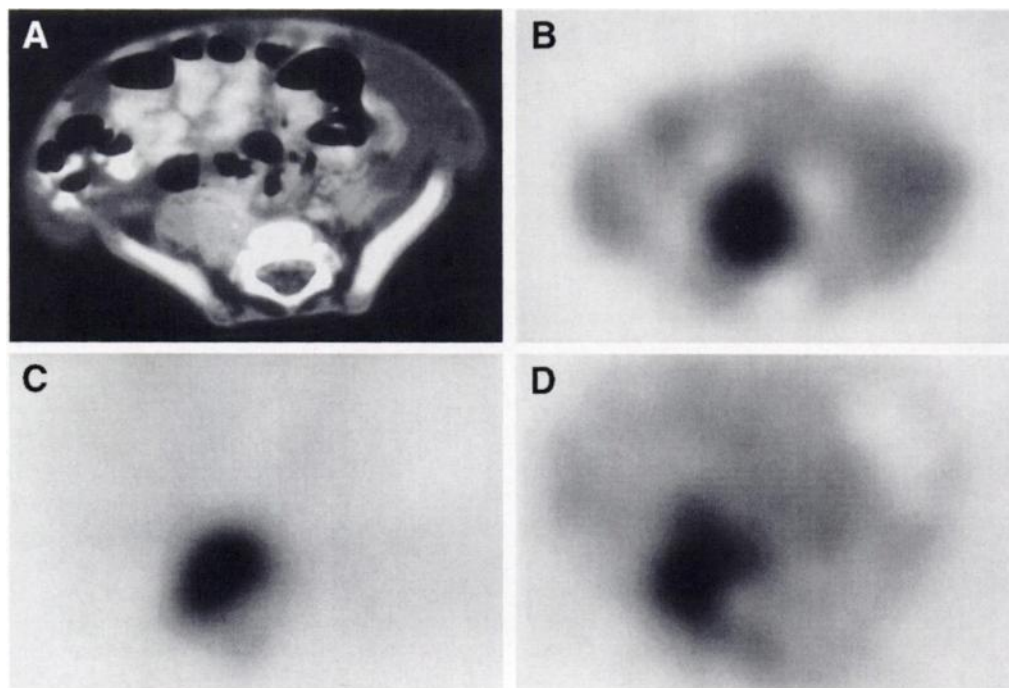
Patient 3. (A) CT scan of the pelvis at 6 mo of age following surgical debulking: There is abnormal soft tissue with speckled calcification in the right posterior pelvis. (B) MIBG-SPECT scan at 24 hr shows uptake into the tumor. (C) HED-PET scan 20 min postinjection. There is excellent uptake within the neuroblastoma, and the image appears similar to the MIBG-SPECT image. (D) FDG-PET scan at 50 min postinjection. There is moderate accumulation of FDG within the mass relative to surrounding background. The tumor, however, appears better delineated with HED.
